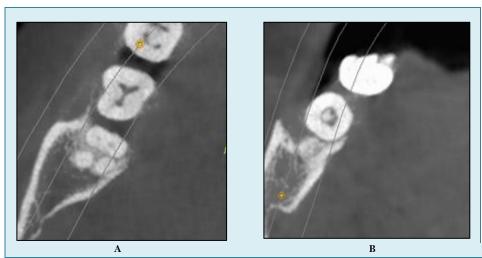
CBCT images (axial view) of mandibular right third molar showing three roots (Radix Entomolaris).
